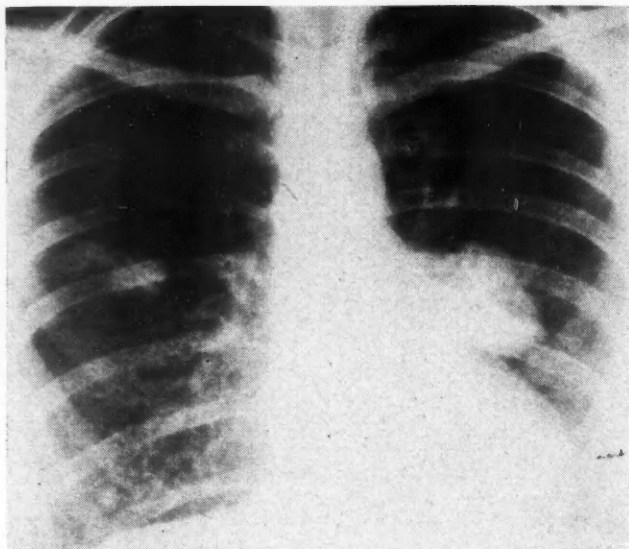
Chest roentgenogram taken February 21, 1959.
